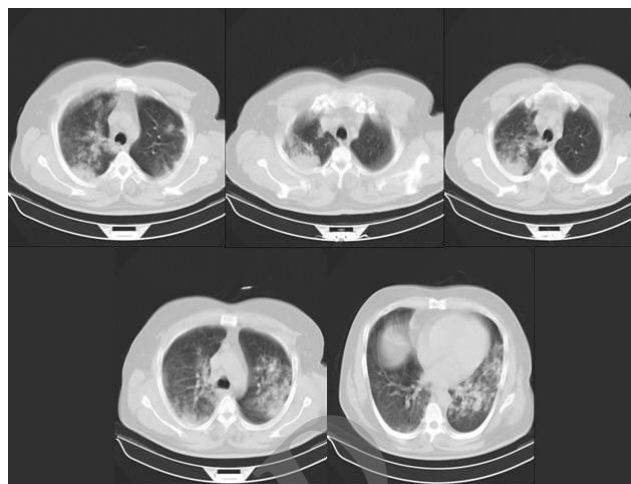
Chest CT scan at the time of admission
